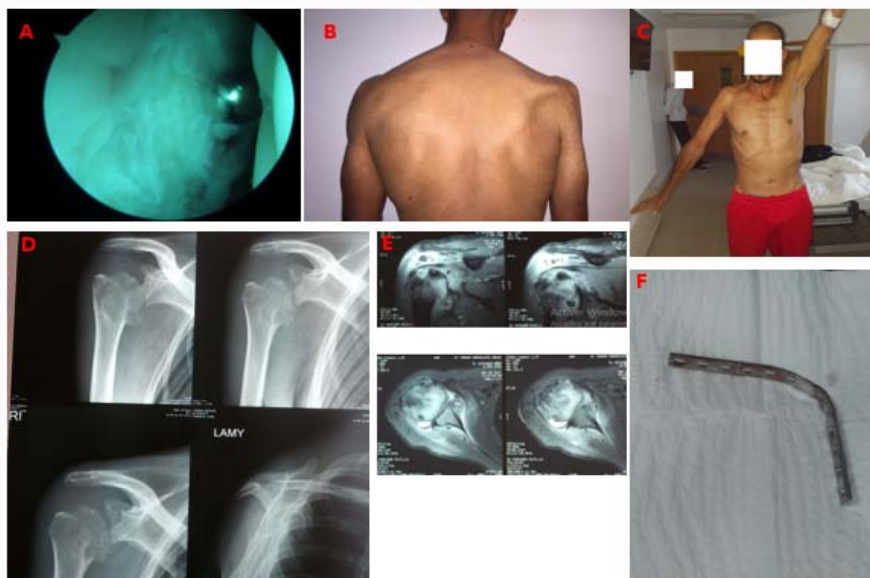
A) Arthroscopic aspect of the glenohumeral joint. B) Clinical aspect on clinical examination there is an amyotrophic deltoid. C) Joint mobility very limited to clinical examination. D) X-ray of the right shoulder incidence anteroposterior and profile de lamy showing extensive destruction of the glenohumeral joint. E) Irm of the shoulder showing a rupture of the rotator cuff. F) Angle of inclination of the DCP plate.
